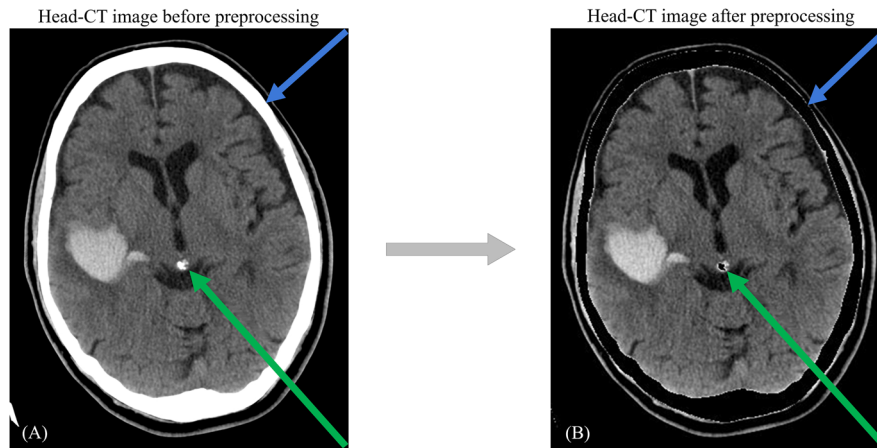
An example of a slice of a head CT scan showing an intraparenchymal hematoma located in the right temporoparietal lobe: before (A) and after (B) the preprocessing. Blue arrows point to skull before and after and green arrows point to the calcified pineal gland before and after
